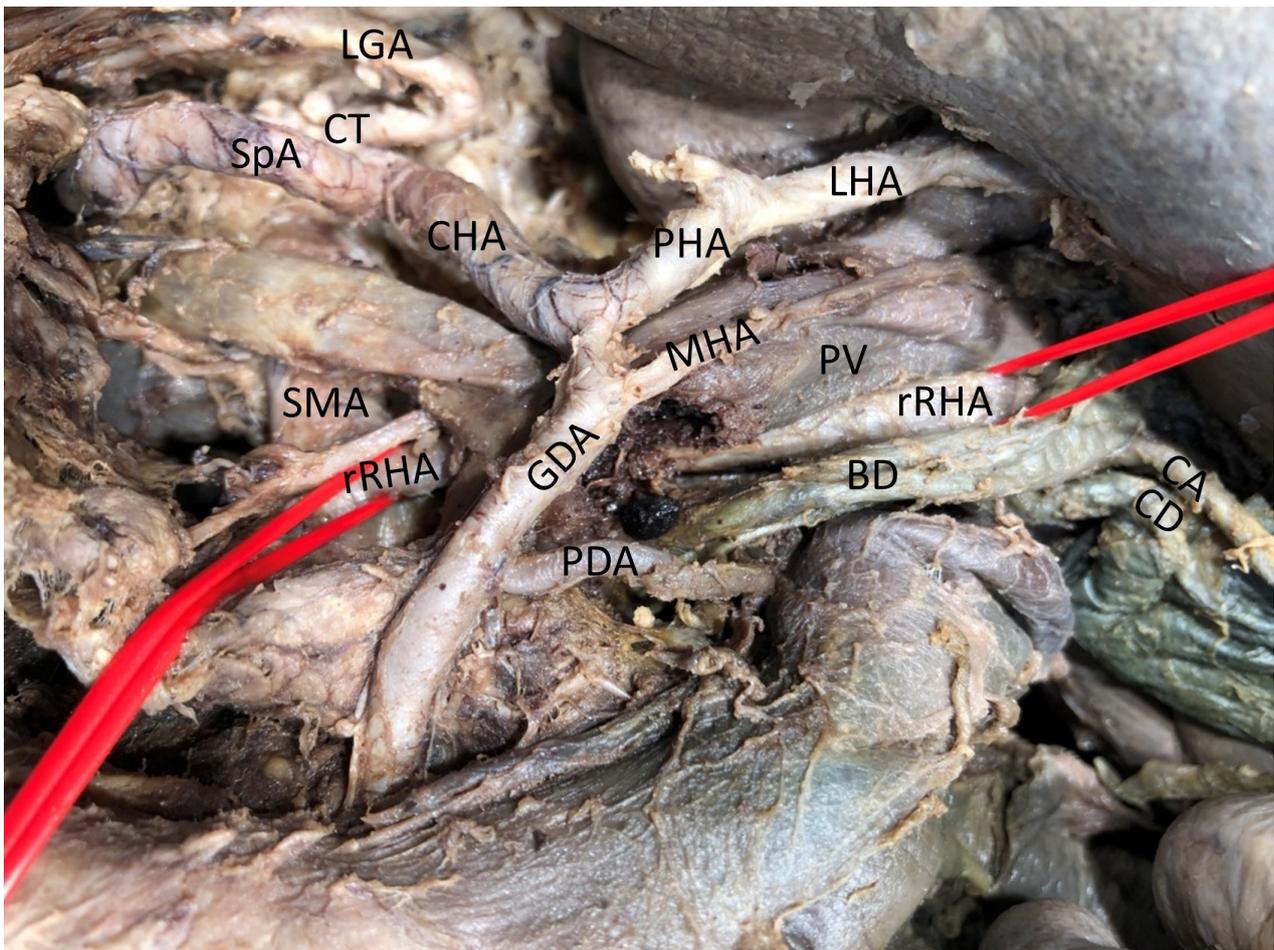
Hepatic arterial variation. Coeliac trunk (CT), superior mesenteric artery (SMA), splenic artery (SpA), left gastric artery (LGA), common hepatic artery (CHA), proper hepatic artery (PHA), left hepatic artery (LHA), replaced right hepatic artery (rRHA), cystic artery (CA), middle hepatic artery (MHA), gastroduodenal artery (GDA), posterior superior pancreaticoduodenal artery (PDA), portal vein (PV), bile duct (BD), cystic duct (CD). The left hepatic artery branched off from the hepatic artery proper that emanated from the common hepatic artery of the coeliac trunk. In addition, there was a replaced right hepatic artery (marked by red ligament), coming from the superior mesenteric artery. An artery branching off from the gastroduodenal artery may constitute a middle hepatic artery (MHA).
